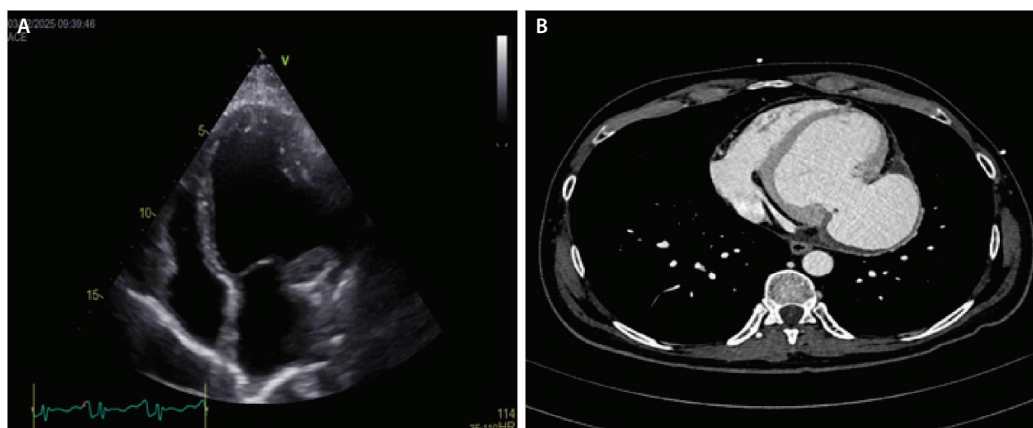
A) preoperative transthoracic echocardiogram: the four chamber view showing pseudoaneurysm (PSAN) of the posterolateral wall; B) preoperative computed tomography: large PSAN in the basal posterolateral wall.
